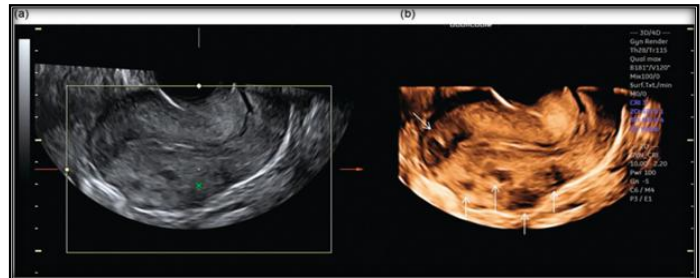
Uterine Fibroids Using Two-Dimensional and Three-Dimensional Ultrasonography
